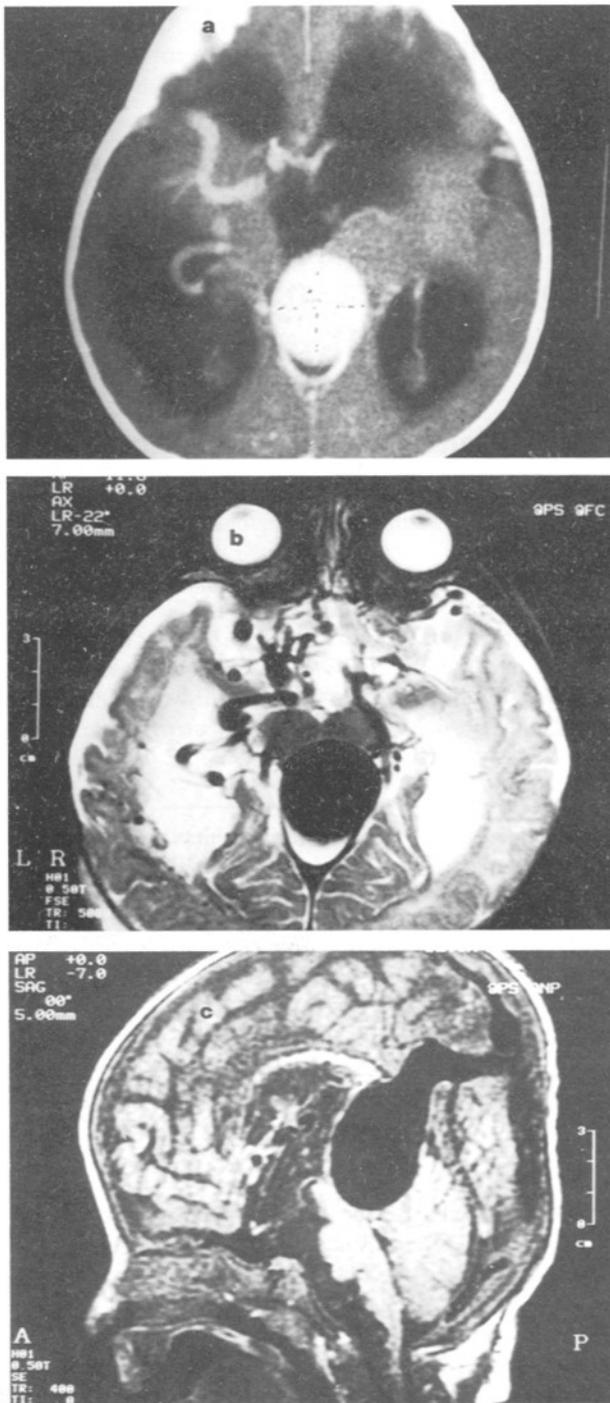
CT scan reveals a 30x32x40-mm enhancing mass in the pineal region, b) axial MR image demonstrates that the both PCAs feed a large aneurysmal dilation, c) sagittal MR image showing accessory straight sinus and stenosis of straight sinus.
